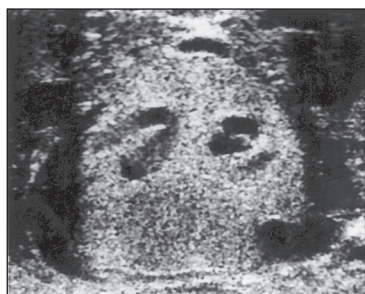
Same patient shows intratesticular varicocele and extratesticular varicocele as hypoechoic structures on gray scale (a) and venous flow in color Doppler sonography (b).
